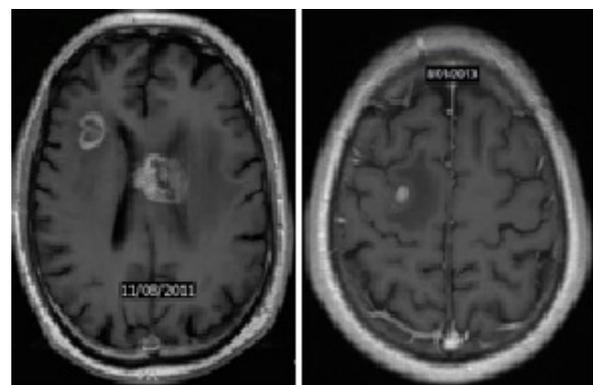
MRI demonstrating CNS oligometastases in two different patients
